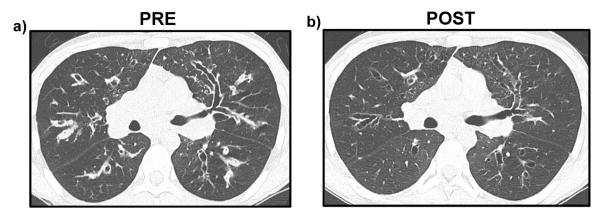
Non-contrast computed tomography scans obtained (a) pre, and (b) post ivacaftor treatment demonstrates an improvement in bronchial wall thickening and mucus plugging.
